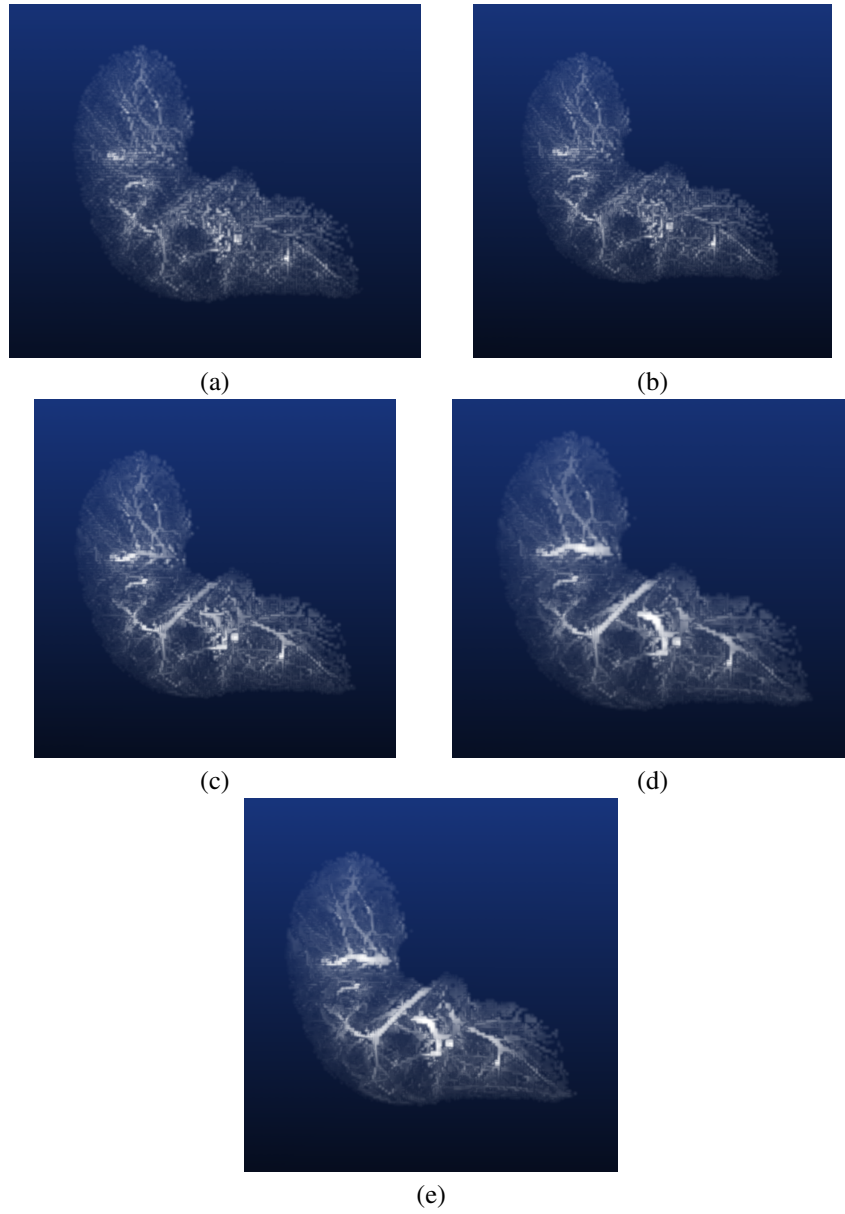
Multi-scale Krissian medialness response obtained for a MRI image of a pre-segmented liver parenchyma. (a)-(d) Single scale responses for $\sigma = 1.25, 1.75, 2.50, 4.0$ (e) Multi-scale response with the maximum criterion.
